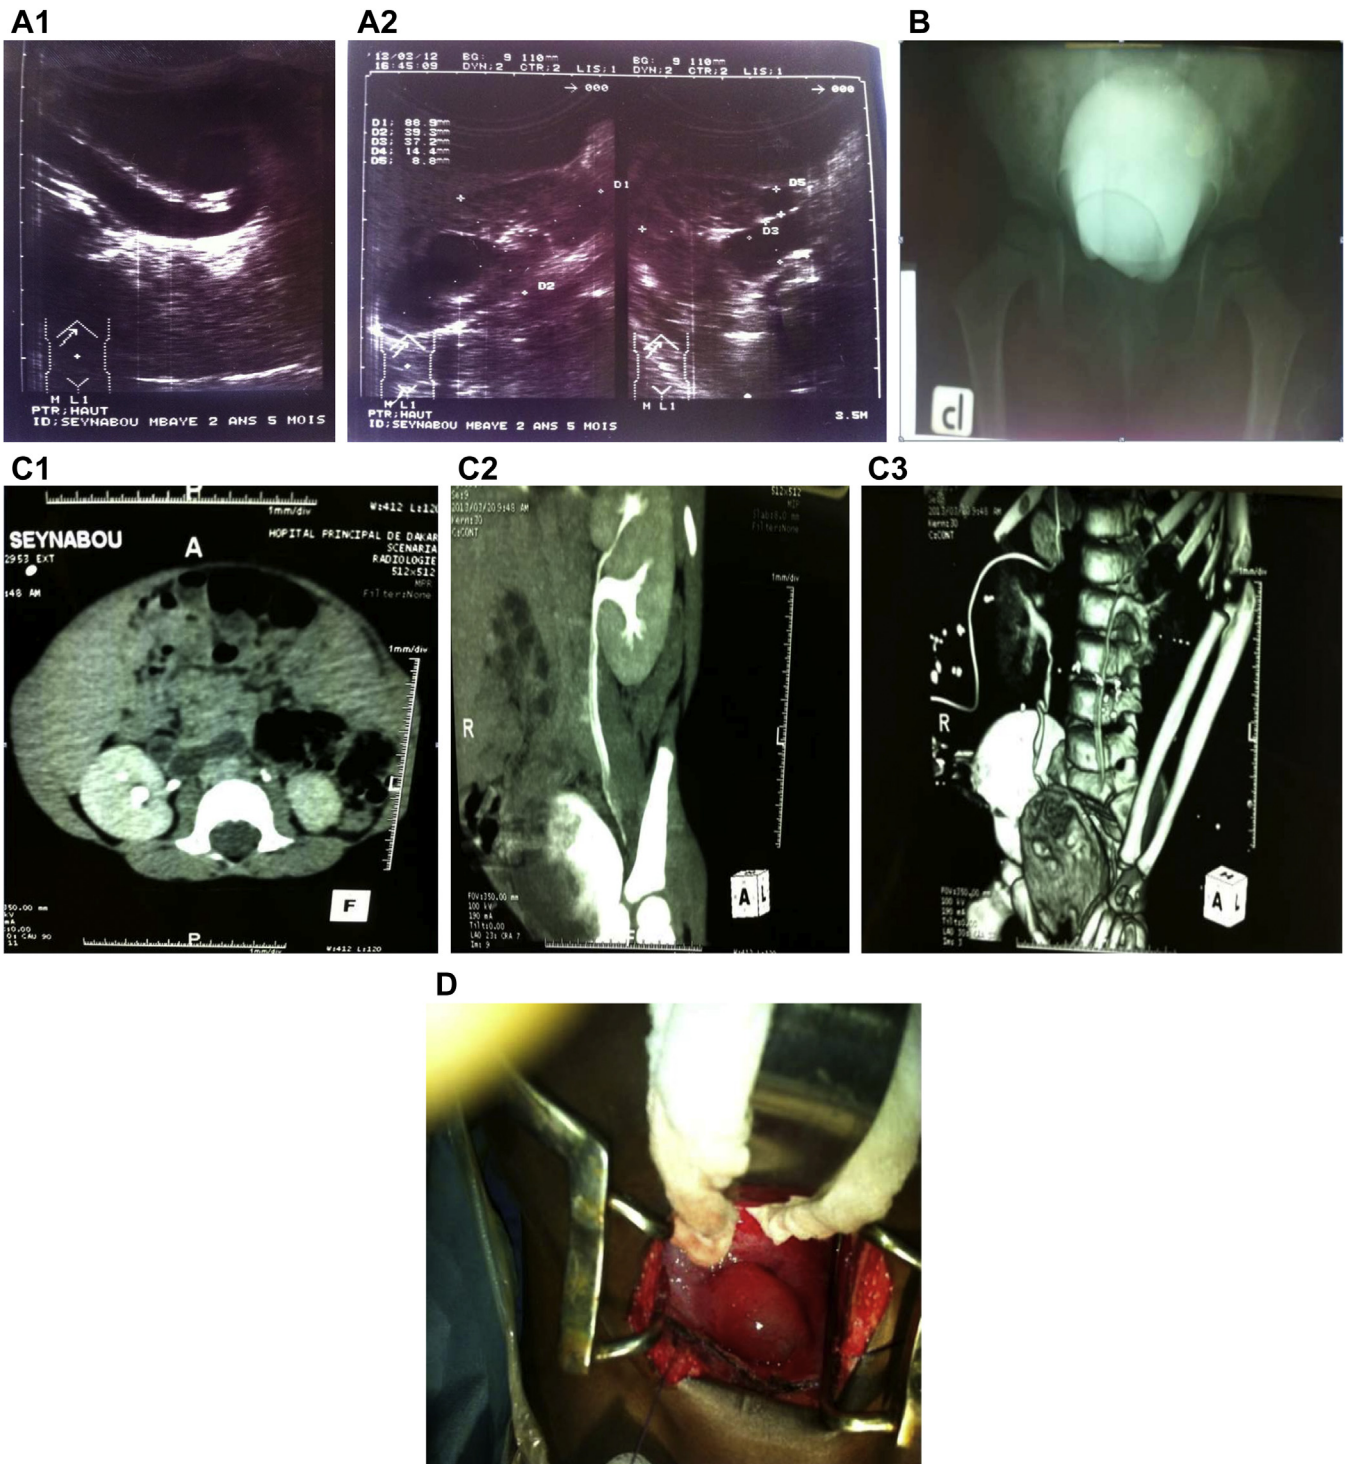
A1: Dilatation of the ectopic ureter behind the bladder neck and intravesical cystic dilatation. A2: Right ureterohydronephrosis of the upper pylon. B: A cystography showing an intravesical filling defect corresponding to the ureterocele and reflux into the ureter of the upper pylon. C1: CT urography in axial section. C2: CT urography in sagittal section showing the right pyeloureteral duplication. C3: Reconstruction with a CT urography that shows right pyeloureteral duplication and a left ureteral bifidity. We note a defect of secretion in the right upper pylon. D: Prolapsed ureterocele at the level of the vesical neck.
